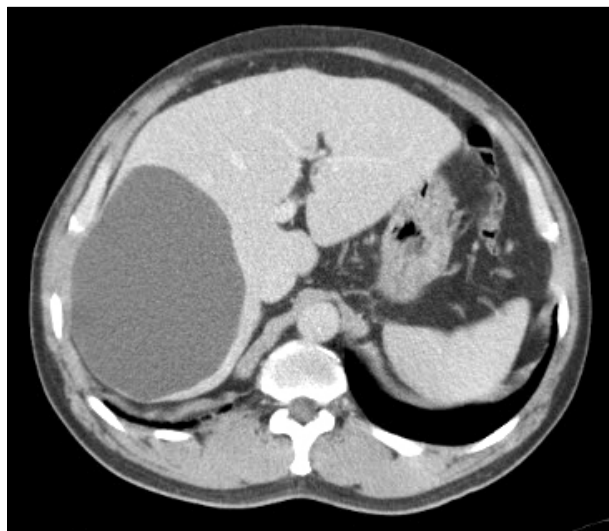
Abdomen computed tomography shows a well-demarcated lesion with low density and without enhancement after contrast administration.
